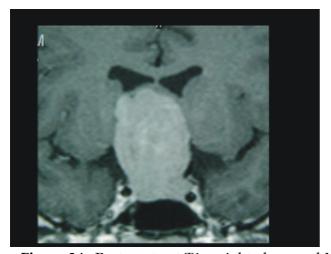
T1-weighted coronal MR image and B. sagittal image showing a Grade I giant pituitary tumor. The tumor does not invade into the cavernous sinus. C. Post-operative sagittal image shows a total excision of the tumor.
